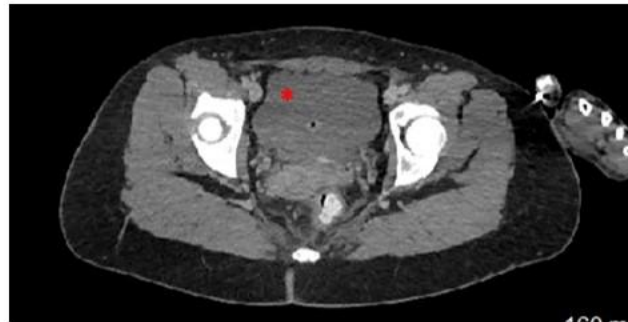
Axial CT with free fluid* sitting cephalad to bladder and catheter balloon visible
